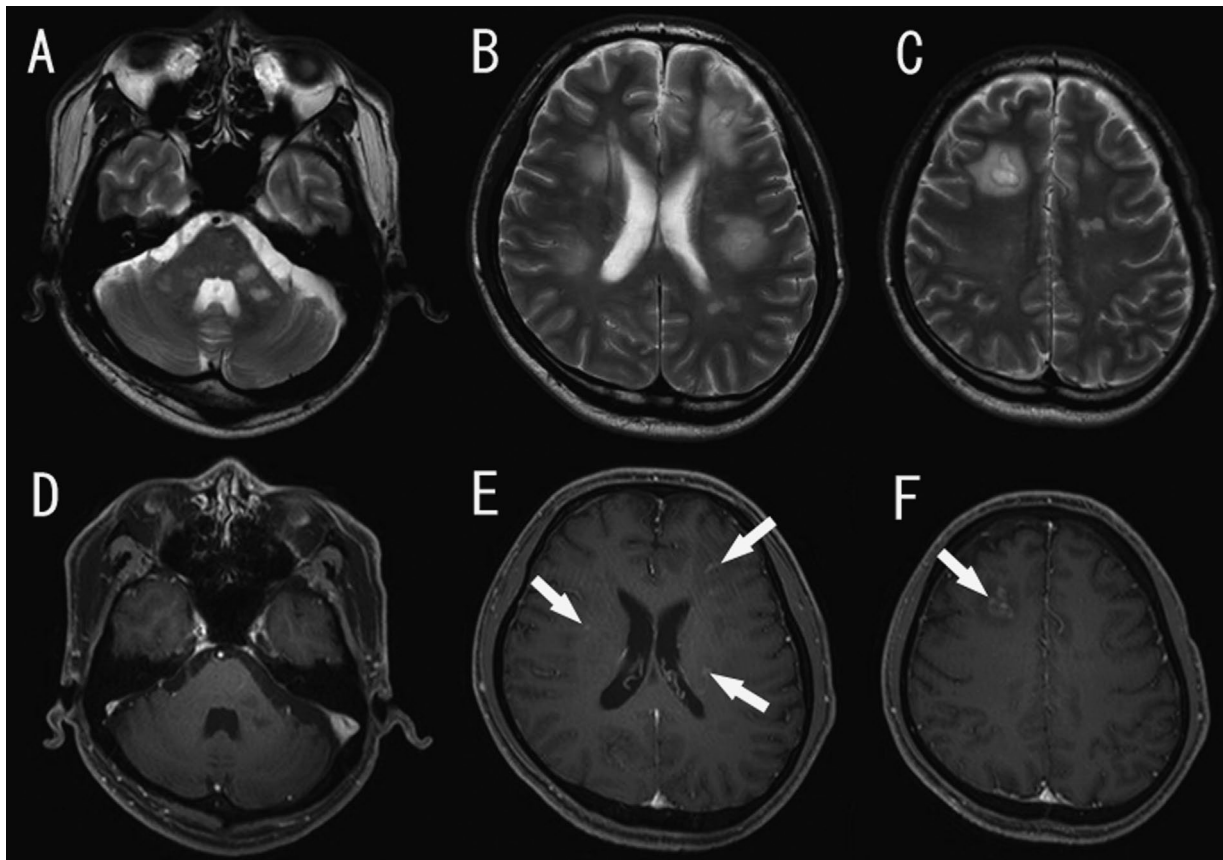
MRI during the fourth hospitalization period. (A-C) T2WI (TR/TE=4000/79) multiple cerebral and middle cerebellar peduncle lesions. (D-F) A T1 contrast-enhanced image (TR/TE=5.82/2.63) showed contrast enhancement in most of the cerebrum lesions (arrow).
